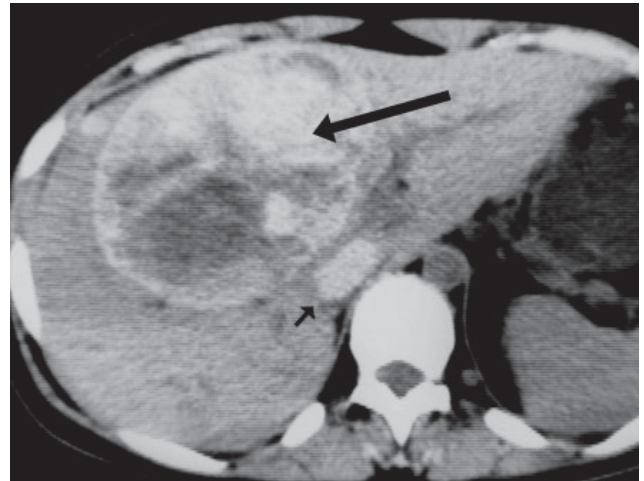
Hemorrhagic metastatic liver tumors, secondary to malignant melanoma. Plain CT shows a large hyperdense bleeding mass at anterior segment of right lobe liver (long arrow). Another smaller lesion is noted (short arrow) which also hyperdense secondary to bleeding.
